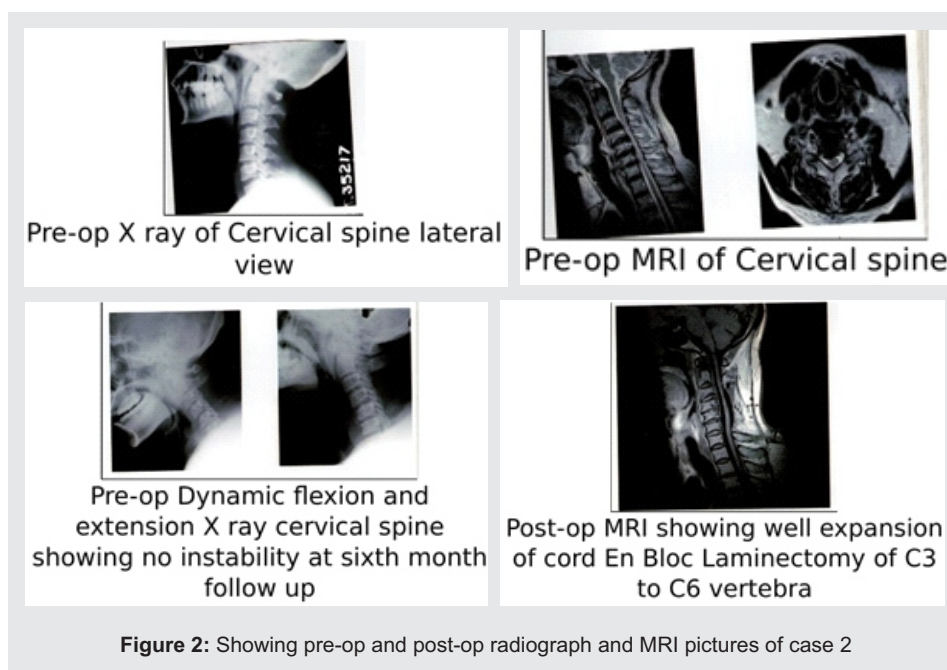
Showing pre-op and post-op radiograph and MRI pictures of case 2
